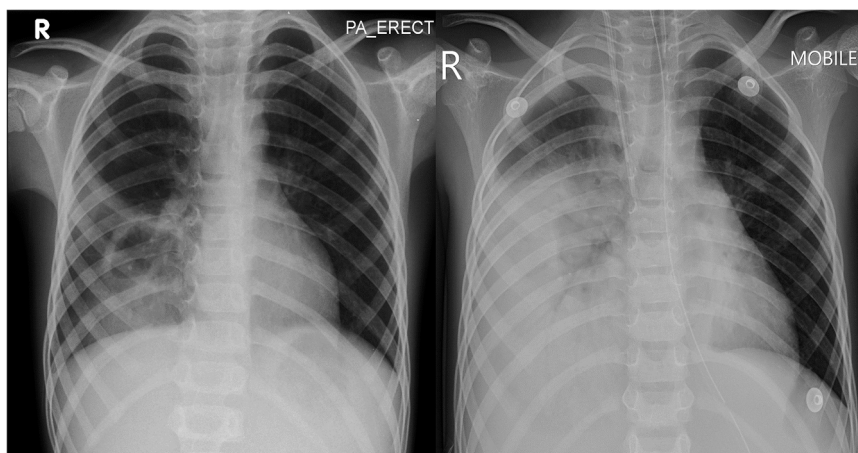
Serial chest radiograph images showing a thick-walled cavity with air-fluid level in the right lower zone at admission (left) which progressed into a fairly homogenous consolidation involving the same region on day-18 of hospitalization (right).
